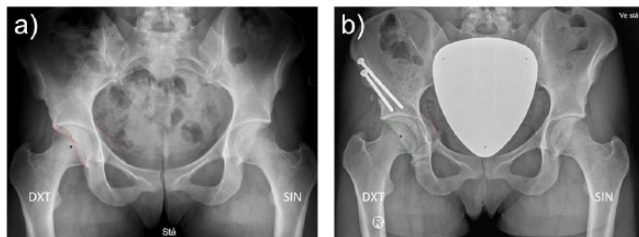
a) Standing anterior-posterior pelvic radiograph with bilateral cross-over sign, posterior wall sign and prominence of the ischial spine. b) One year post-operative standing anterior-posterior radiograph. The osteotomies are healed and the cross-over sign and posterior wall sign have disappeared.
